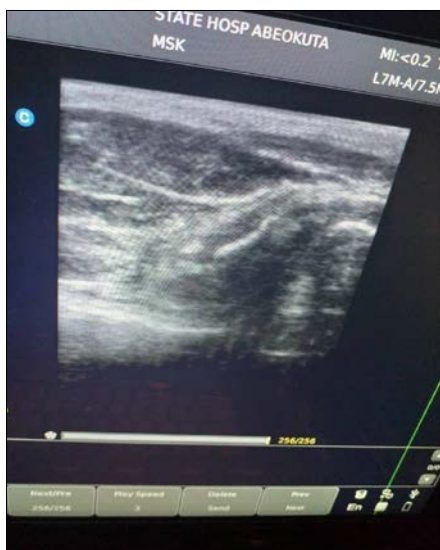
Ultrasound scan of the left hand
